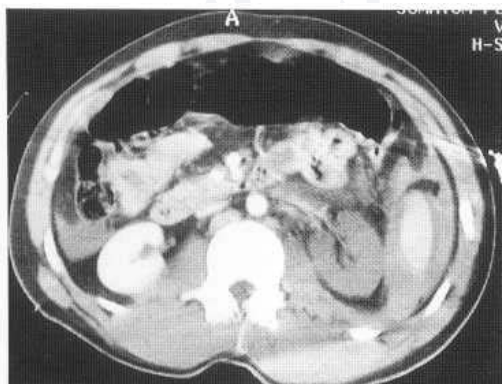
Contrast CT of traumatic renal arterial avulsion. The left kidney is completely non-enhancing (non-perfused). There is a small amount of blood along the line of the renal vessels and a modest haemorrhage related to the spleen.
